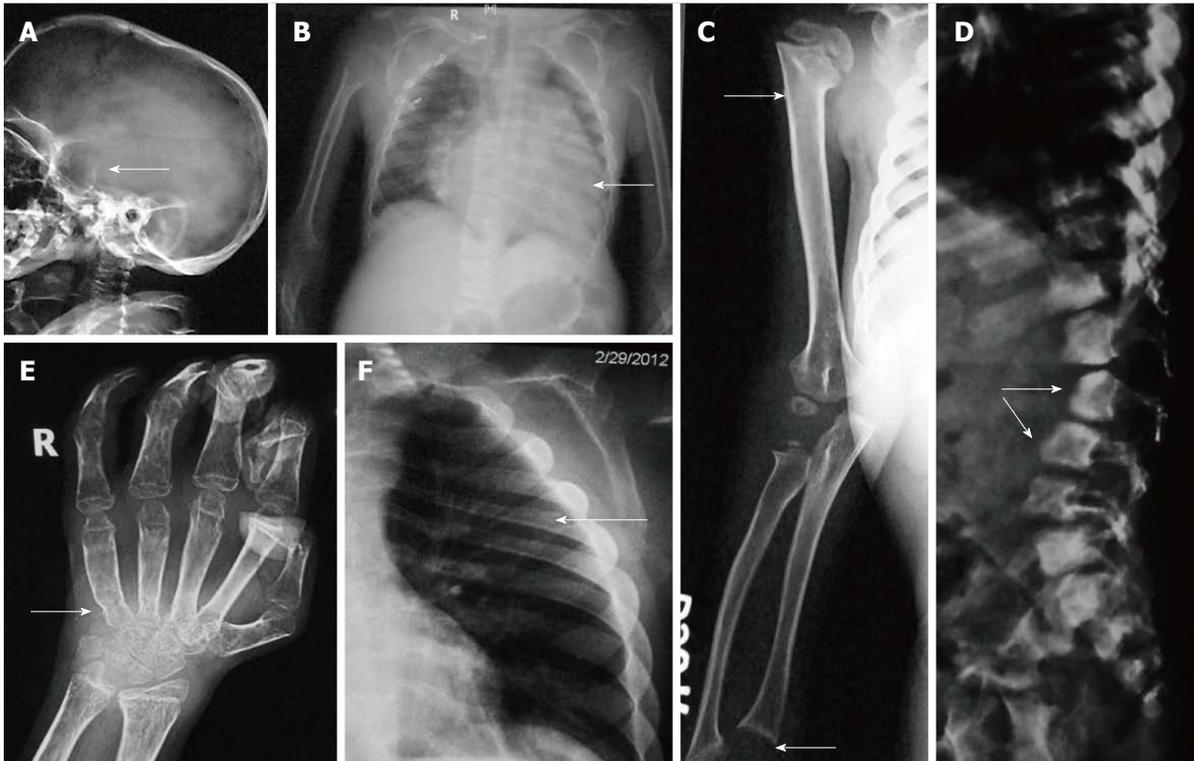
Hurler's syndrome. Radiographs of patient with Hurler's syndrome show macrocephaly with enlarged J-shaped sella (arrow, A), cardiomegaly (arrow, B) and paddle-shaped ribs (arrow, E). Also note relative diaphyseal widening in humerus (upper arrow, C) and sloping lower ends of radius and ulna (lower arrow, C). Radiograph of hands (D) shows proximal pointing (arrow), osteopenia and flexion deformities in distal interphalangeal joints, Radiograph of spine (F) shows hypoplastic L1 and antero-inferior beaking (arrows).
